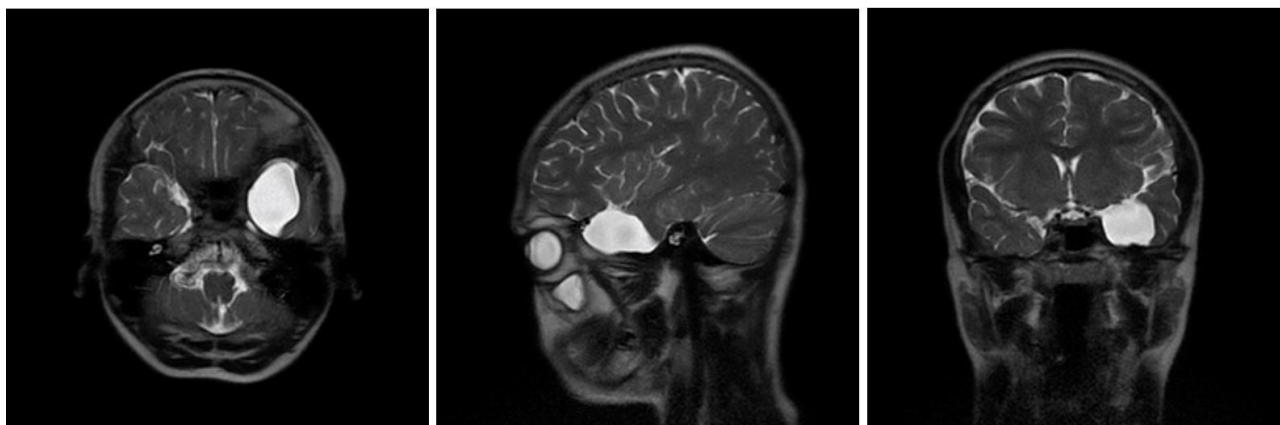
Axial, sagittal and coronal fast brain MR images demonstrating an arachnoid cyst in the left middle cranial fossa in a 13-year-old-male
